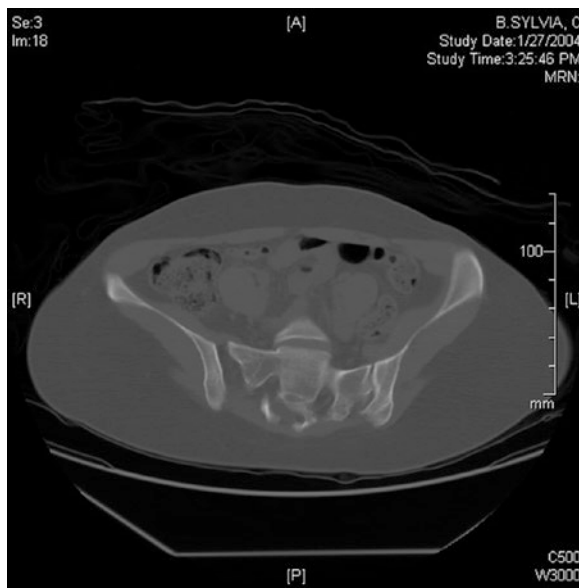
An axial CT of an anomalous sacrum with the anterior surface of the *left* ala more posterior than the anterior surface of the *right* ala. This can be difficult to appreciate on intraoperative fluoroscopy and creates a shallow “safe zone” for passage of the screw
